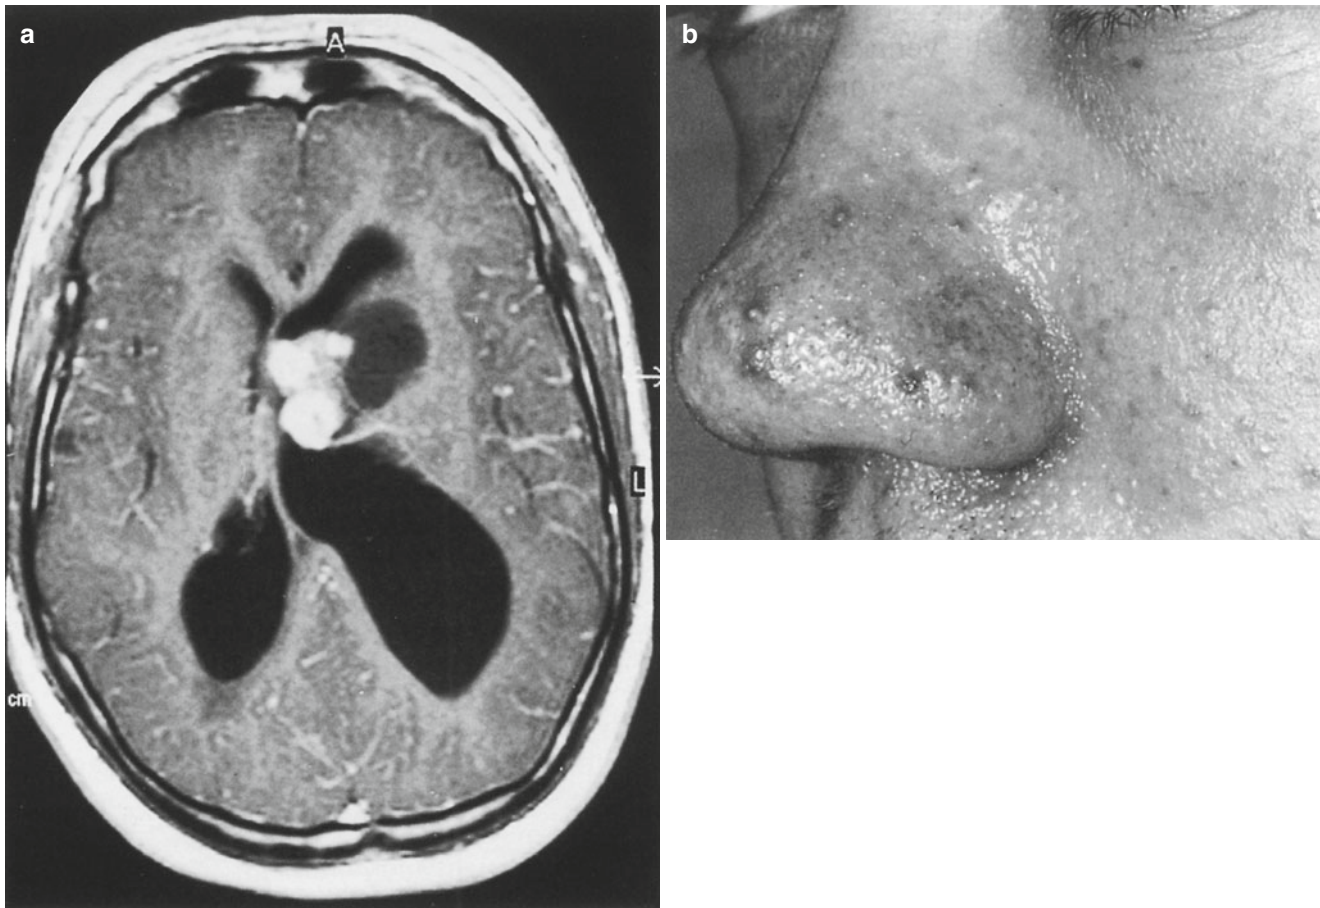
(a) Axial T1-weighted MRI with gadolinium showing a giant cell astrocytoma at the Foramen of Monro in an adolescent patient with tuberous sclerosis. (b) The classical facial angiofibromas (adenoma sebaceum) of tuberous sclerosis
